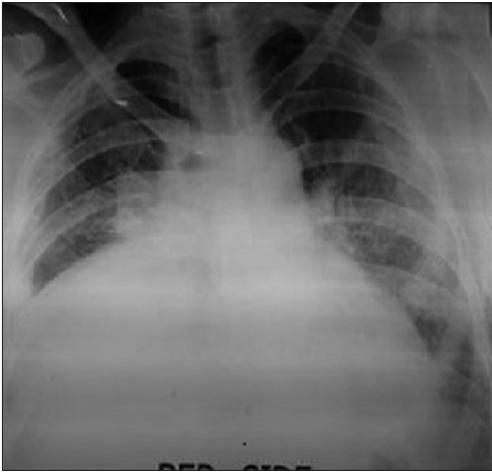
Chest X-ray PA view; on the day of admission, showing homogeneous opacity right mid and lower chest
